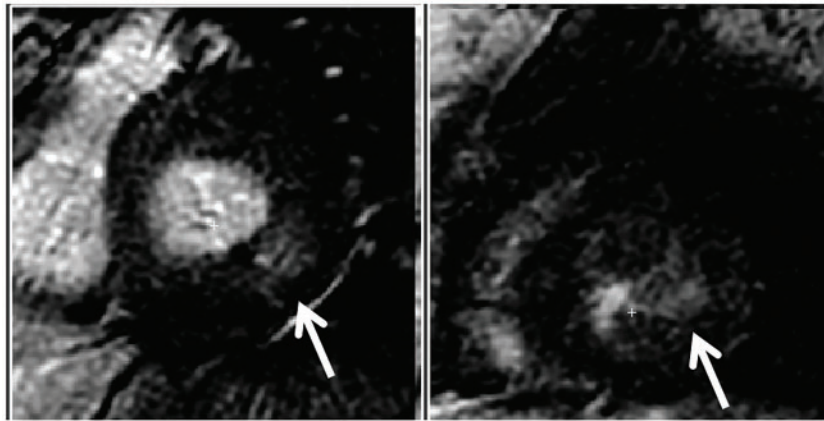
Late enhancement cardiac magnetic resonance images showing late gadolinium enhancement (arrows) in the infero-lateral wall of the left ventricle.
